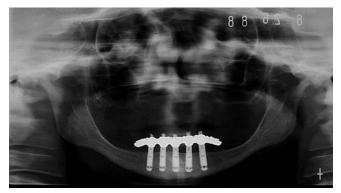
E, Panoramic radiograph shows suprastructure on the implants for the hybrid denture–type prosthesis.
